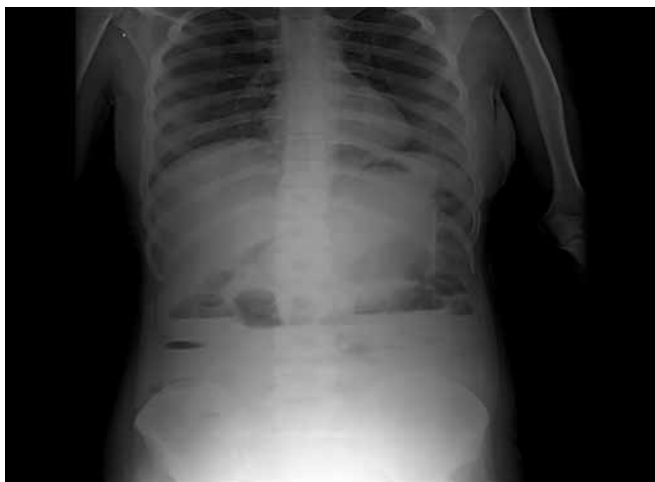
Erect abdomen X-ray showing multiple air fluid level
